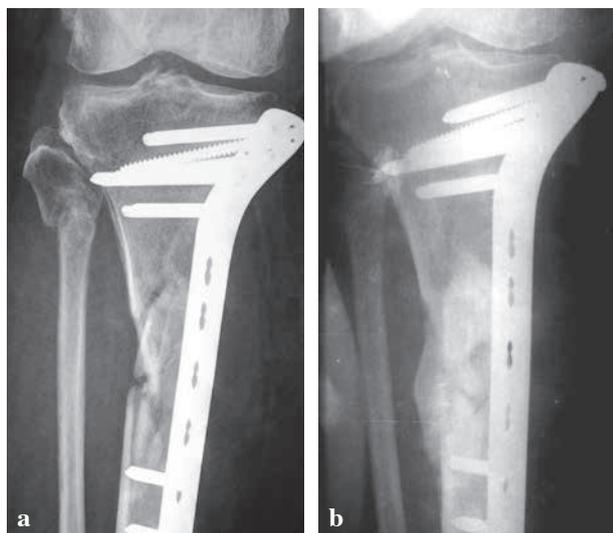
Plain AP radiograph showing a comminuted fracture of the proximal tibia internally fixed with a locked plate with a varus angulation which was accepted in this specific patient : a) no signs of union 8 months post fixation ; b) union of fracture 5 months post injection of bone marrow.
